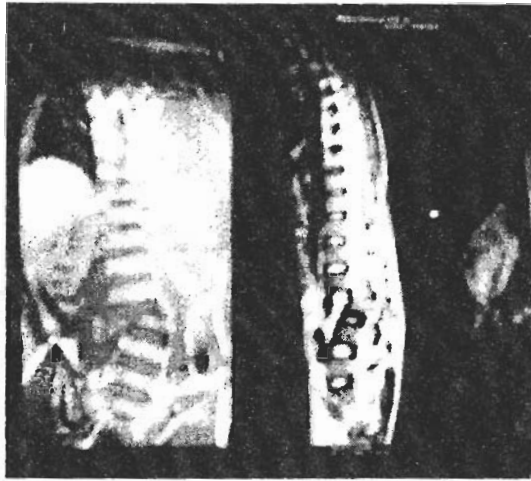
MRI showing severe spinal fracture; ureteric injury in a blunt abdominal trauma indicates the severity of the trauma.
